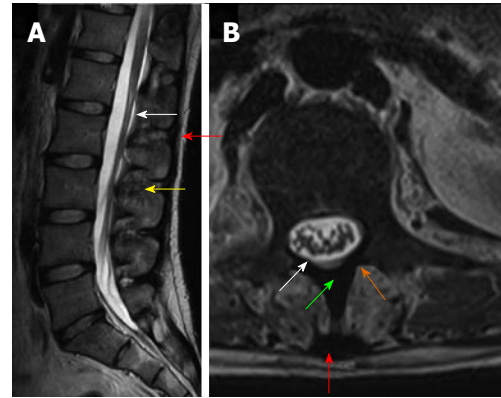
Magnetic resonance anatomy of the spine. T2 weighted sagittal magnetic resonance (MR) image (A) and T2 weighted axial MR image (B) show posterior ligamentous complex with ligamentum flavum (white arrow), interspinous ligament (yellow arrow) supraspinous ligament (red arrow), spinous process (green arrow) and lamina (orange arrow).
